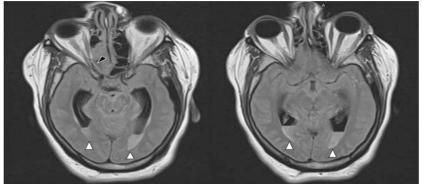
T2 Image from MRI without contrast. Showing ventriculitis and meningitis. On these images you can clearly see the fluid-fluid levels in the ventricles (white arrow tip), as well as right ethmoid sinus inflammation impinging on the soft tissues and nerves entering the right orbit (black arrow tip).
